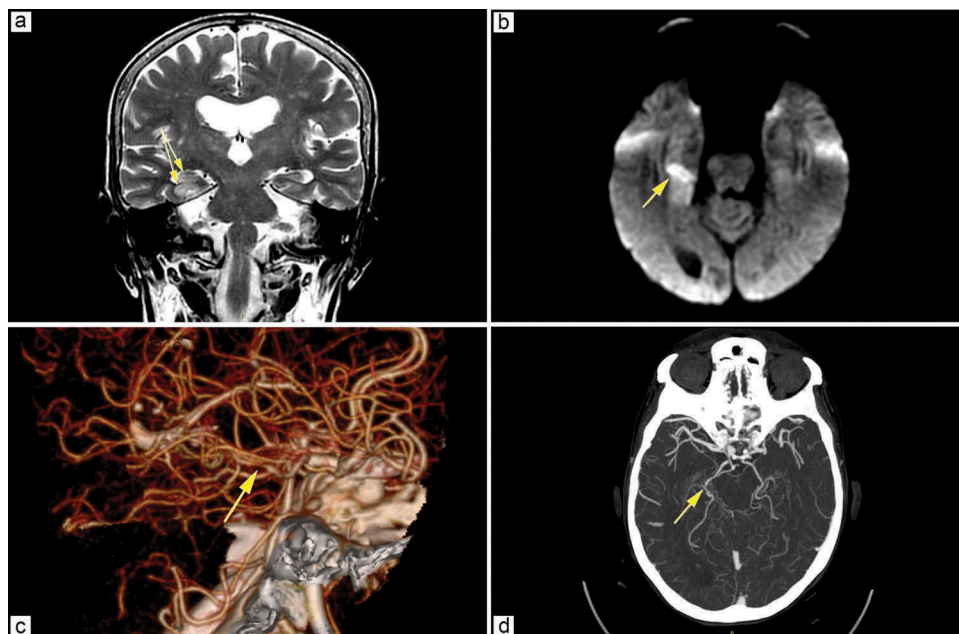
Brain MRI displays signal hyperintensity of right hippocampus and para-hippocampus on Fluid Attenuated Inversion Recovery (a) and DWI (b) sequences (see yellow arrows). A focal stenosis (about 3 mm) of the P2P segment of right posterior cerebral artery is documented by CT angiography [3-D (c) and Maximum Intensity Projection (d) reconstruction; yellow arrows].
